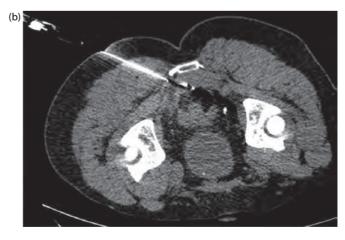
(a) Images from positron emission tomography CT in four different planes. The patient had a history of anterior resection for rectal carcinoma. There is evidence of abnormal activity in the left presacral region suspicious for recurrence. (b) CT-guided Tru-cut biopsy using an 18 G needle was performed exactly at the same level of activity as shown in (a).
